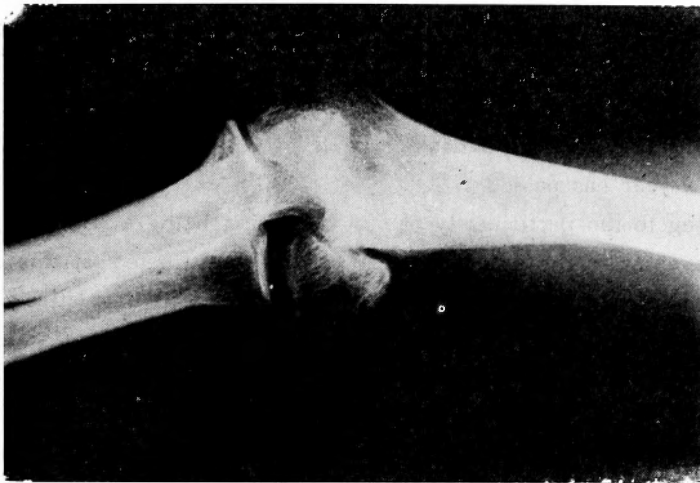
Case #6 Roentgenological findings. Old epicondylar fracture.
